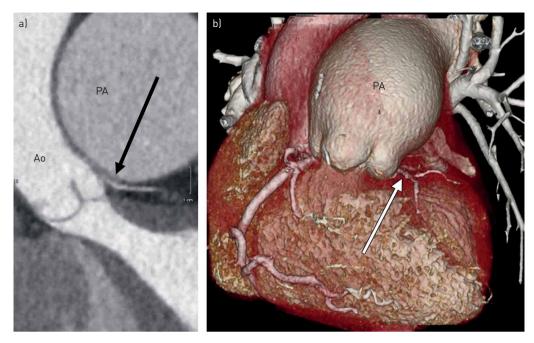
Images show long-standing pulmonary arterial hypertension from connective tissue disease (scleroderma) with compression of left main coronary artery. a) Multiplanar reformation of left main coronary artery origin from left sinus of Valsalva shows compression (arrow) by massive pulmonary artery (PA). b) Volume-rendered coronary CT angiography shows enlarged pulmonary trunk (PA) and very small left main coronary artery (arrow). Ao: aorta.
